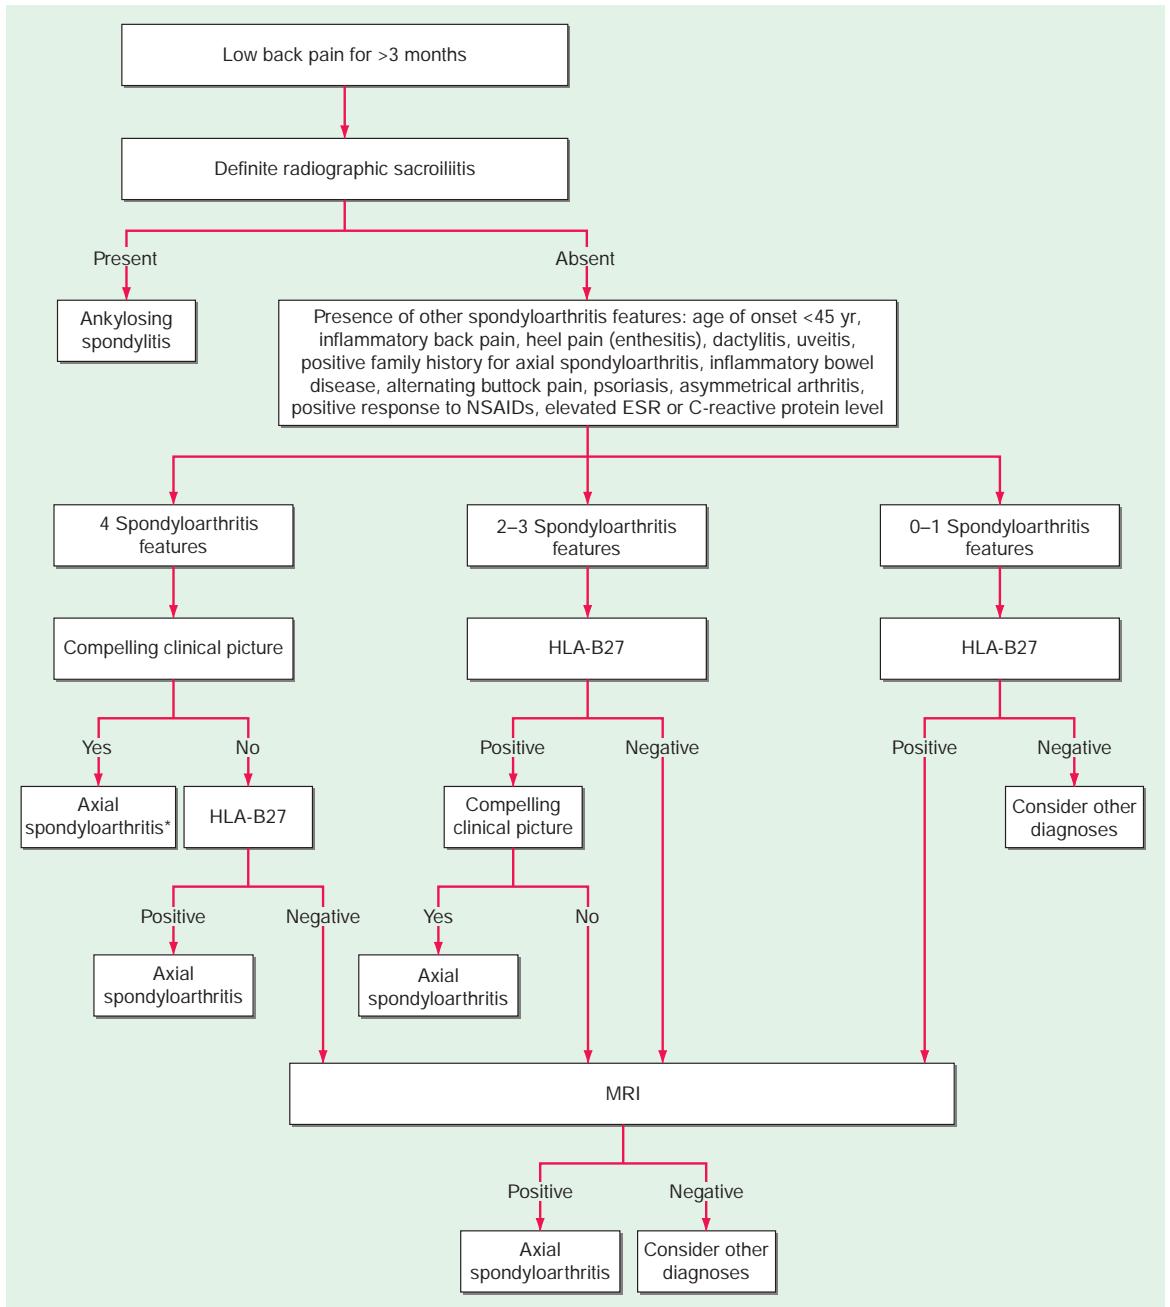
Algorithm for the diagnosis or exclusion of axial spondyloarthritis. The algorithm is designed for use in patients with at least a 3-month history of unexplained chronic low-back pain. Definite radiographic sacroiliitis is based on the modified New York criteria for ankylosing spondylitis (*van der Linden S et al: Arthritis Rheum* 27:361, 1984). The algorithm is adapted from *van den Berg R et al: Ann Rheum Dis* 72:1646, 2013. The determination of whether or not a clinical picture is compelling is based on the relative weights of the spondyloarthritis features (Feldtkeller E et al: *Rheumatology [Oxford]* 52:1648, 2013) and on clinical judgment. The list of clinical features includes features of both axial and peripheral spondyloarthritis. *Confirming MRI is recommended. (From Taurog JD et al: *N Engl J Med* 374:2563, 2016.)
